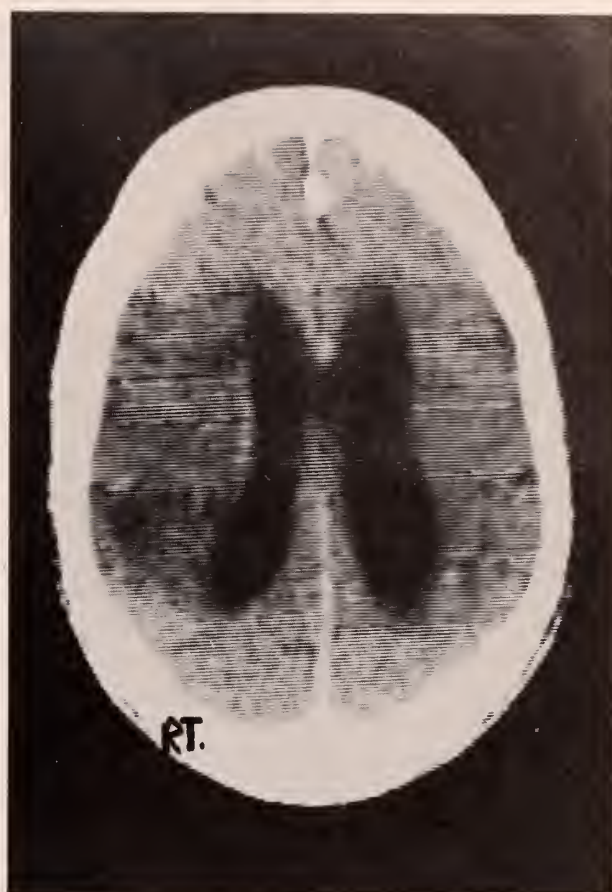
Case 2, late post contrast CT scan, one month after stroke.
